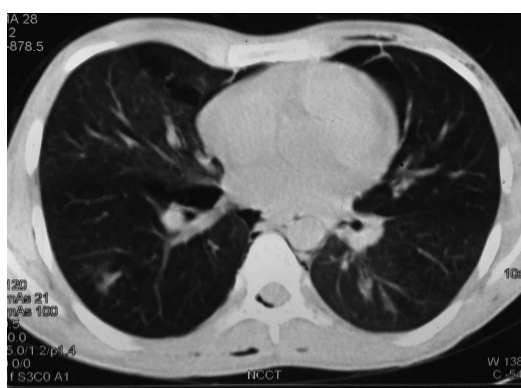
Computed tomography showing pneumomediastinum and pneumorachis and subcutaneous emphysema.
